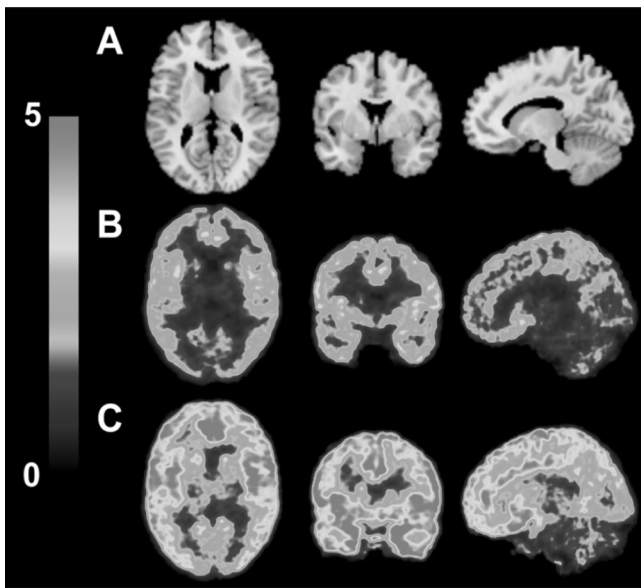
Template MR (a) and co-registered positron emission tomography (PET) images summed from 30 to 90 min after ^{11}C -EKAP injection for high (b) and low (c) Barratt Simplified Measure of Social Status (BSMSS) score individuals. Activity is expressed as SUV [concentration/(injected dose/body weight)]
